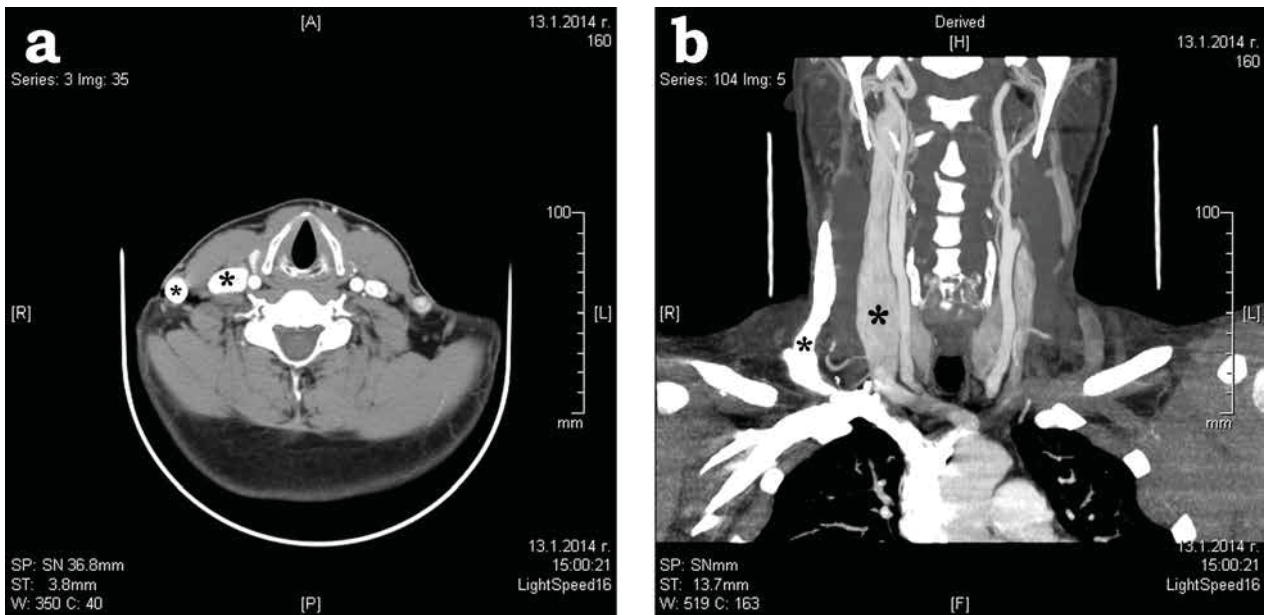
Transverse (a) and frontal (b) sections of the patient's body seen on contrast CT angiography showing the dilated IJV (big asterisk) and external jugular vein (small asterisk).
